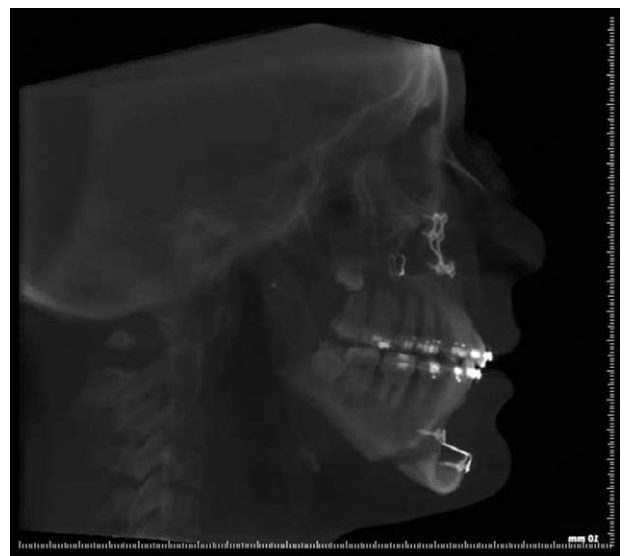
Bilateral mandibular distraction osteogenesis and deferred Lefort I osteotomy, genioplasty, and rhinoplasty (patient 5). Lateral x-ray: 1 year post surgery.
